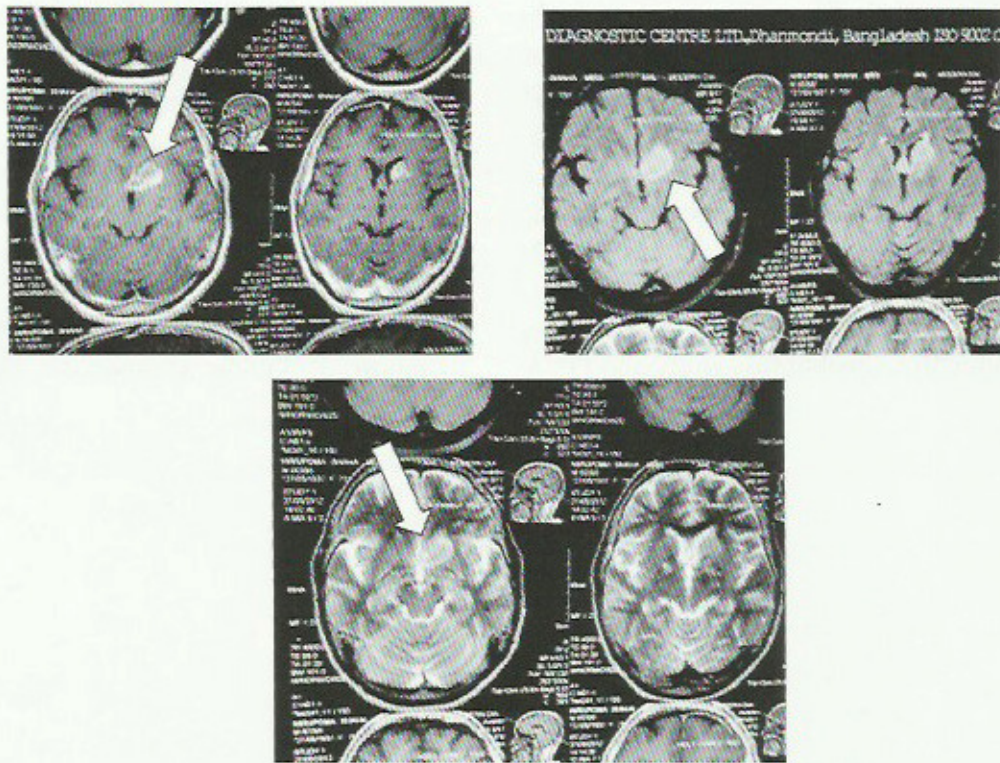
MRI shows lobulated mass lesion in left basal ganglion region.
